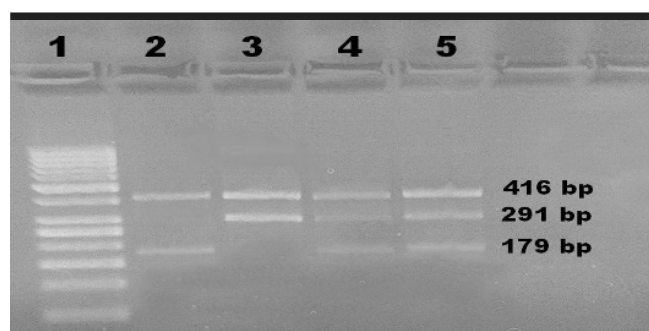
Agarose gel showing PCR-CTPP analysis of the *klotho* c.1767C>T variant. Lane 1 shows 50 bp DNA ladder, lane 2 shows the homozygous TT genotype, lane 3 shows the homozygous CC genotype, lanes 4 and 5 show the heterozygous CT genotype.
